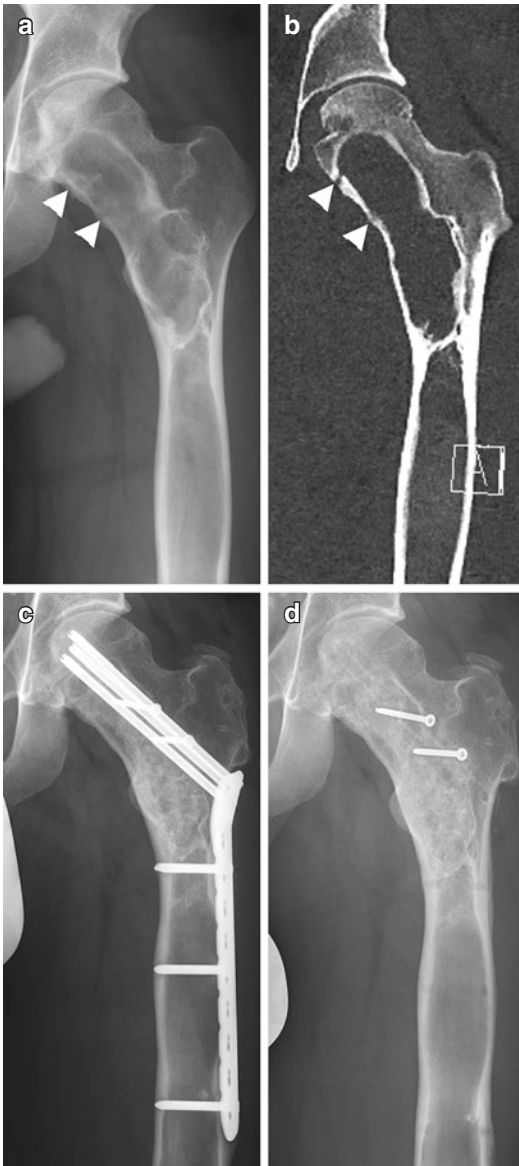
25 year old male diagnosed with polyostotic fibrous dysplasia. The patient developed progressive hip pain with ambulation. X-ray and CT scans demonstrated an extensive osteolytic lesion and an un-displaced fracture at the calcar (marked with arrowheads, (a, b)). The patient was treated with curettage through an anterior cortical window, bone grafting with impacted allogeneic bone and plate osteosynthesis of the proximal femur. The postoperative course was uneventful with complete bone reconstitution of the proximal femur after 2 years (c). Plate removal was performed 27 months after the index surgery (d)
